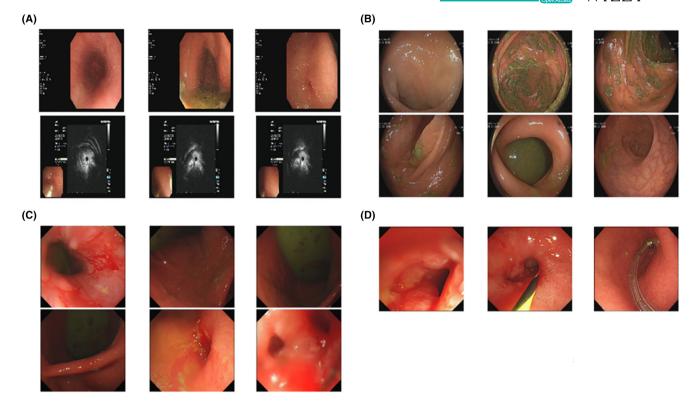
Videography results of cases. (A) The examination of miniature ultrasonic probe of case 1 revealed that gastric mucosa is smooth, and a large amount of food residues can be seen; pyloric stenosis, which can't be passed by endoscope; ultrasonography revealed hyperechoic thickening of the duodenal mucosa. (B) There was no organic lesion in the entire large intestine during electronic colonoscopy of case 1. (C) Painless gastroscopy of case 2 showed the mucosa of the lower esophagus is strip-shaped erosion, and the mucosa of cardia is scattered in sheet ulcer. A large amount of green food was found in the stomach. The pylorus is deformed, the anterior wall forms a diverticulum, the mucosa in the diverticulum is congested and edema, and the anterior wall of the pyloric canal forms an ulcer. (D) In case 2, endoscopic jejunely feeding tube placement was performed, painless gastroscopy revealed descending duodenal stenosis with pseudodiverticulum formation at the anterior wall.
